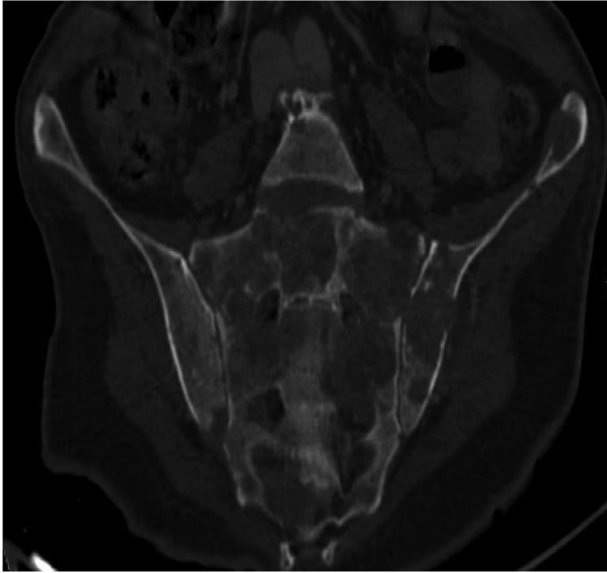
CT scan of the pelvis showing osteolytic lesions.
